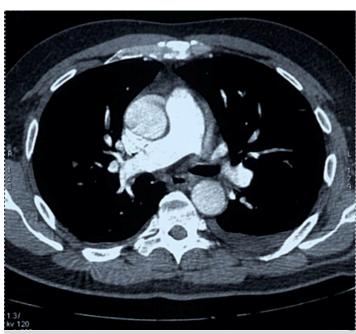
CT of the thorax: thrombosis in lobar branches of the right pulmonary artery.
